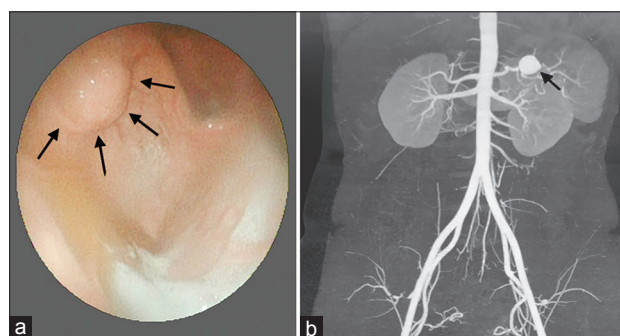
The protrusion effect of a mass seen endoscopically in the patient's stomach (fundus) lumen (a, arrows). Computed tomography angiography image of the splenic artery aneurysm (b, arrow).
